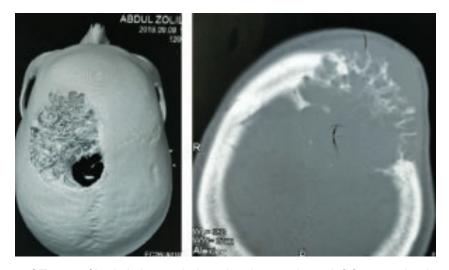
CT scan of brain in bone window showing erosion at left frontoparietal region.
